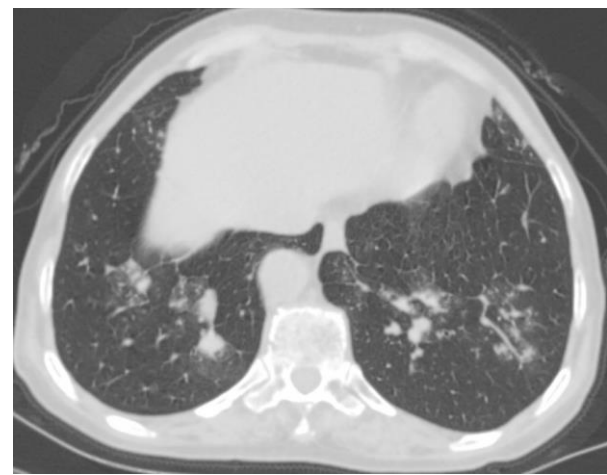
A 59-years-old female patient with influenza A. CT scan demonstrated multiple mixed ground-glass opacity along the bronchial vascular bundle with many solid components and high density.
